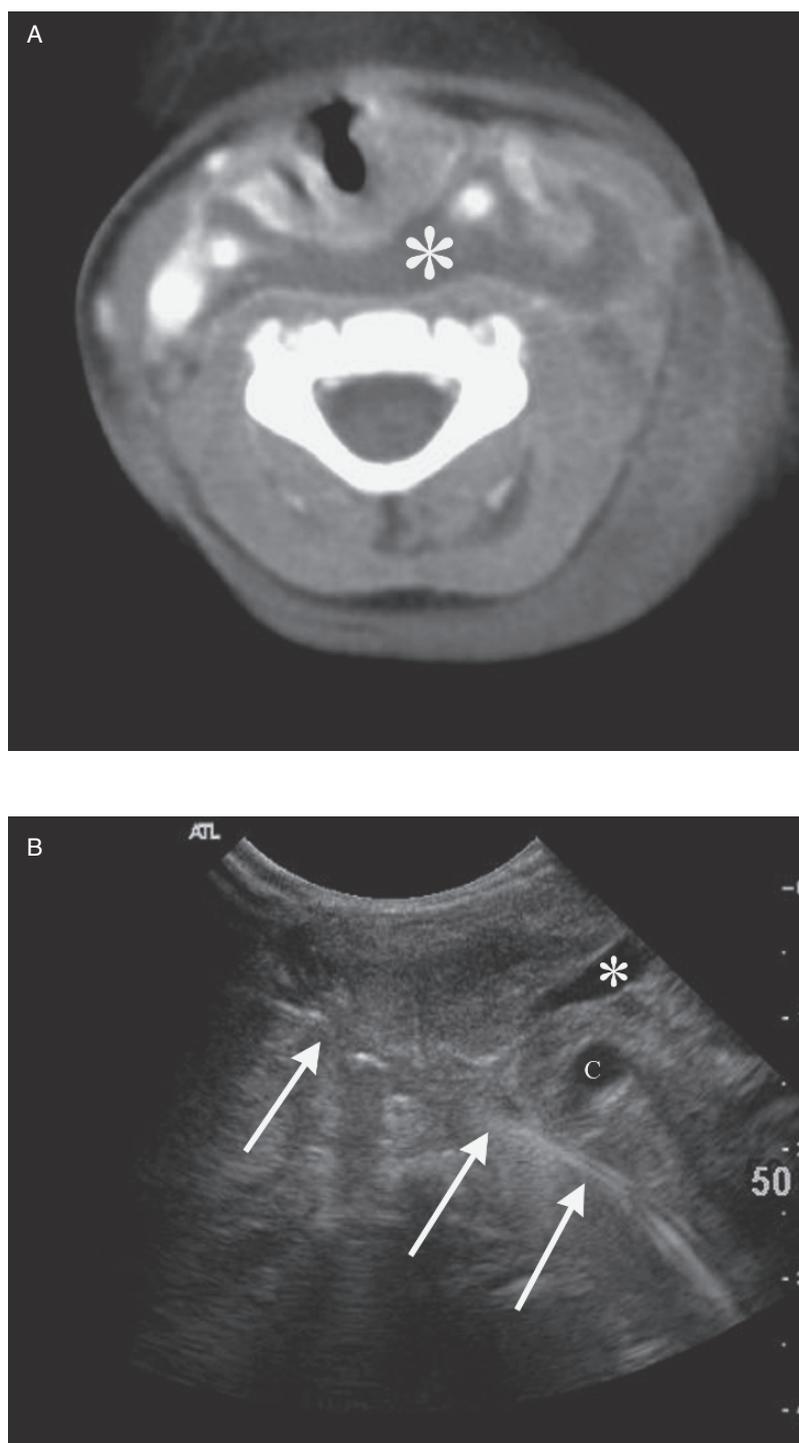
Patient with fever after tonsillectomy. (A) There is a retropharyngeal abscess (*). (B) Demonstrates ultrasound guidance to place a drainage tube (arrows) into the abscess avoiding the carotid artery (C) and the jugular vein (*).
